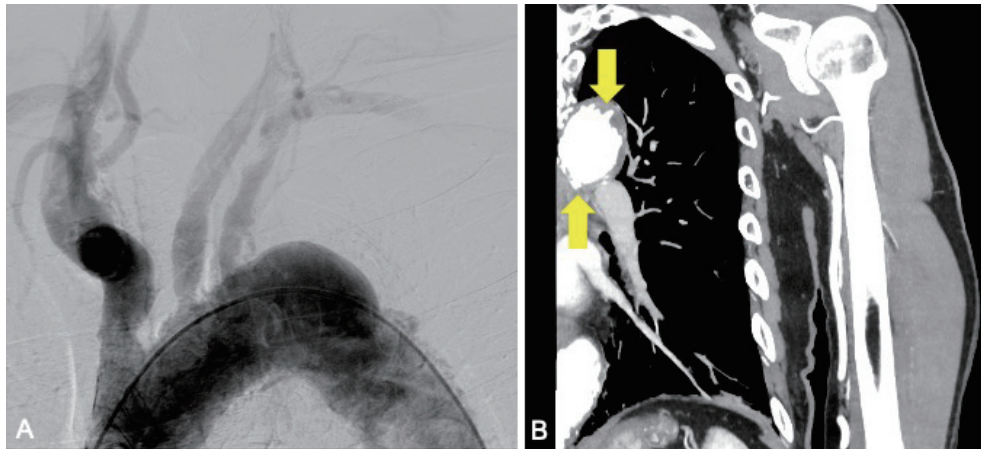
Aortography and contrast-enhanced CT
